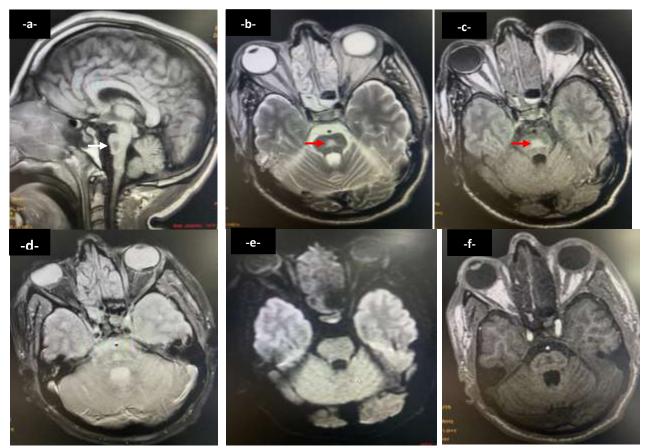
Brain MRI showing a triangular-shaped, with posterior base, centropontine signal anomaly, hyposignal on the sagittal T1 sequence (a, white arrow), hypersignal on the axial T2 (b) and T2 FLAIR (c) (red arrow), without hemorrhagic remodeling on the T2* sequence (d), without restriction of diffusion (e) and not enhanced after injection of Gadolinium (f).
